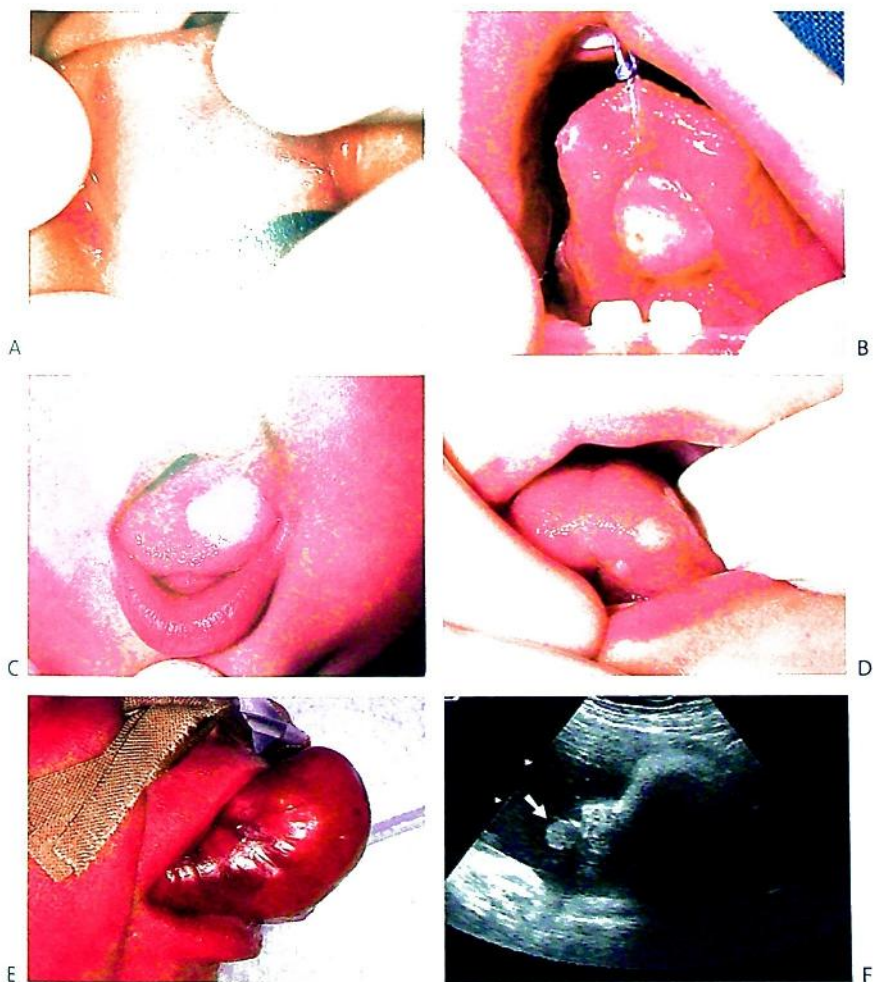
Oral pathology in infants. (A) Bohn's nodules in a newborn child (arrow). (B) Fibroepithelial hyperplasia on the ventral surface of the tongue caused by trauma from the erupting mandibular incisors. (C) White sponge naevus of the tongue. (D) Granular cell tumour. (E) Congenital epulis measuring 4 cm in length. (F) The lesion was diagnosed prenatally on ultrasound (arrow).
